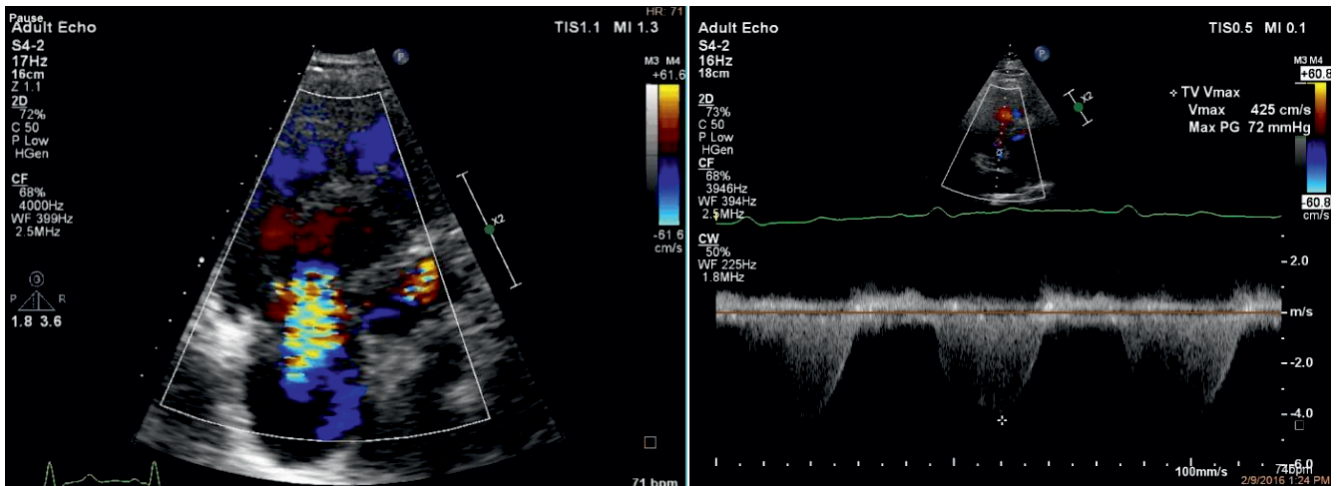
Transthoracic echocardiography apical view, color Doppler, continuous wave Doppler, sPAP 80 mmHg.
